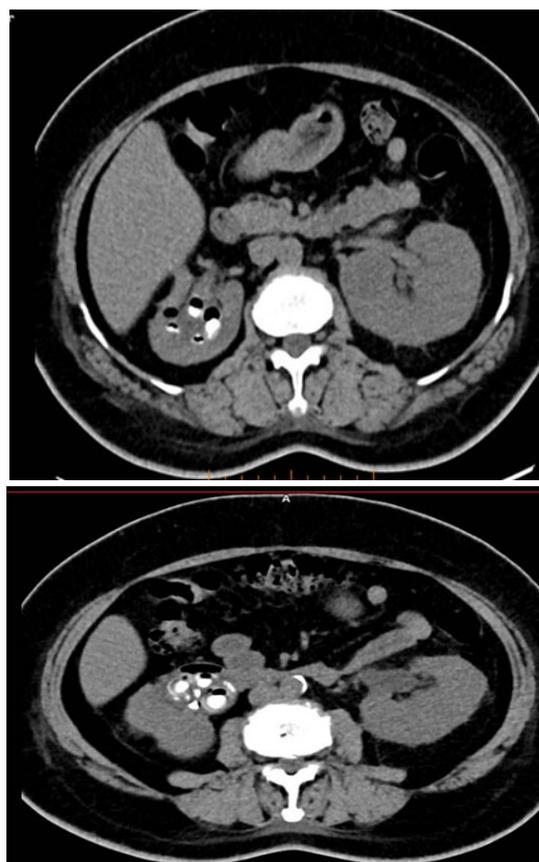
Nonenhanced computed tomography (CT) images in a case report of Emphysematous pyelitis
